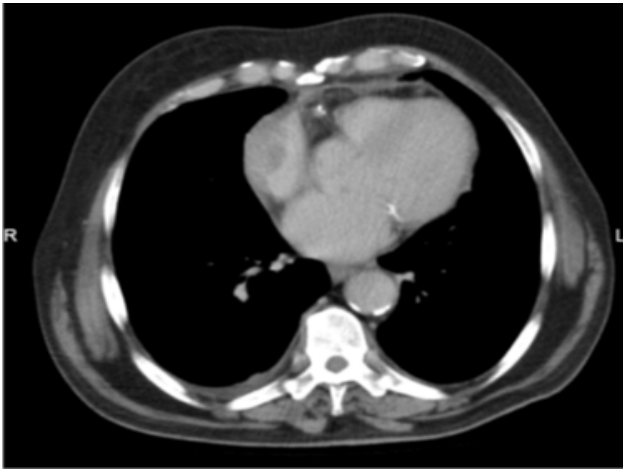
Computed tomography (CT) of the heart.
